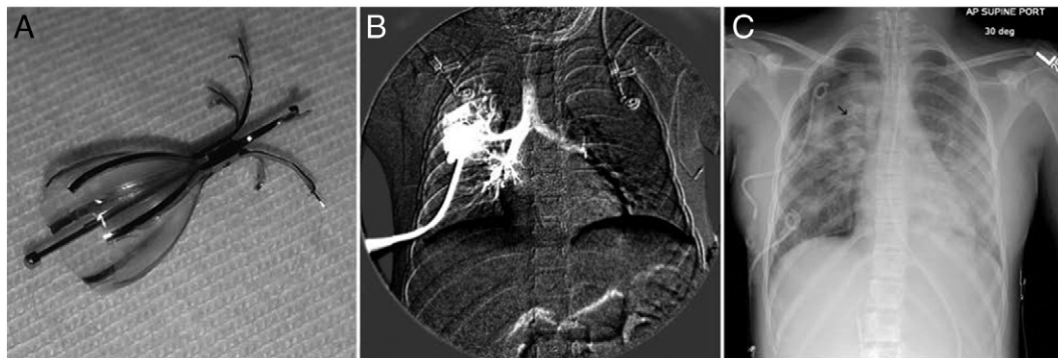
A) Endobronchial valve. B) Patient A fistulogram. C) Patient C plain chest radiography. Arrow indicates location of three right upper lobe valves immediately after placement.
